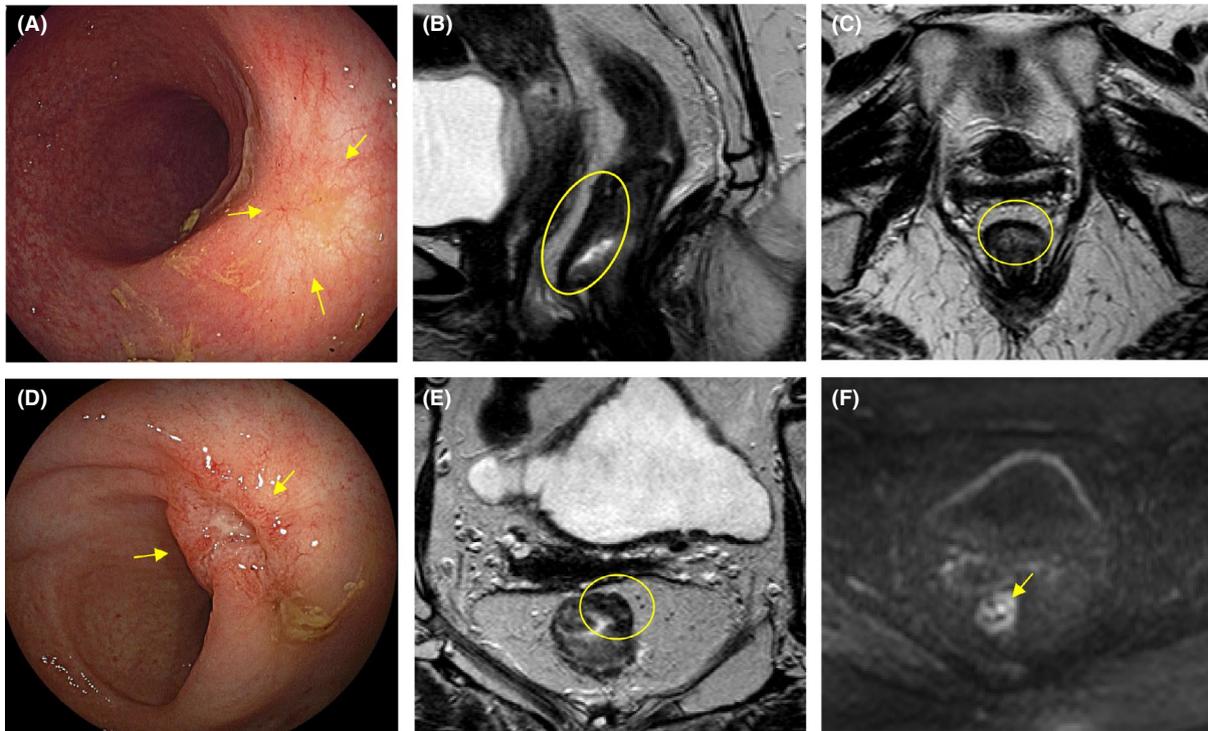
Example of patient with rectal cancer with a clinical complete response after neoadjuvant treatment. (A) White scar tissue and telangiectasia (yellow arrows) on endoscopy and (B) corresponding fibrotic wall on sagittal and (C) transversal T2-weighted MR images (indicated in yellow). Six months later, (D) there is an ulcer with elevated edges on endoscopy (yellow arrows) and (E) tumour mass is visible on transversal T2-weighted MR images within the fibrotic tumour bed with (F) diffusion restriction on diffusion-weighted imaging, suspicious for a local regrowth
